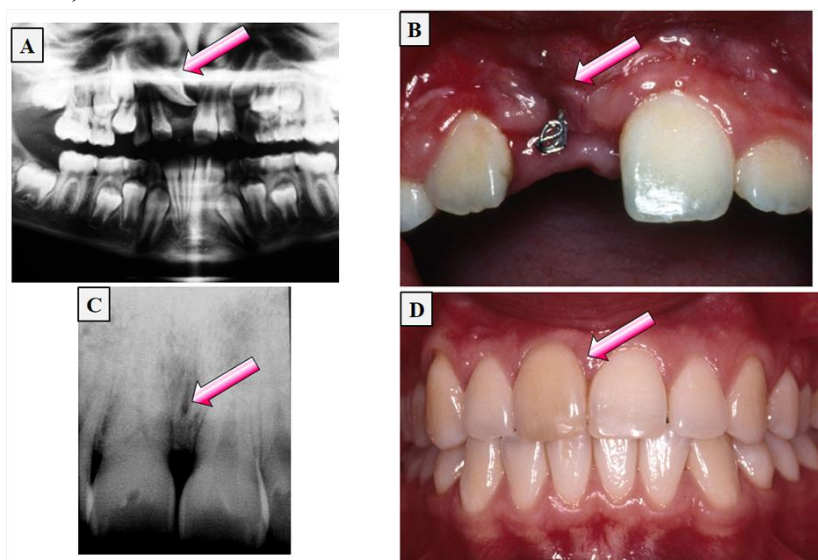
A-D: Trauma-induced dilaceration, positional alteration, and labial impaction of the permanent maxillary central incisor (tooth 11) following trauma to the primary anterior teeth: clinical and radiographic follow-up.
